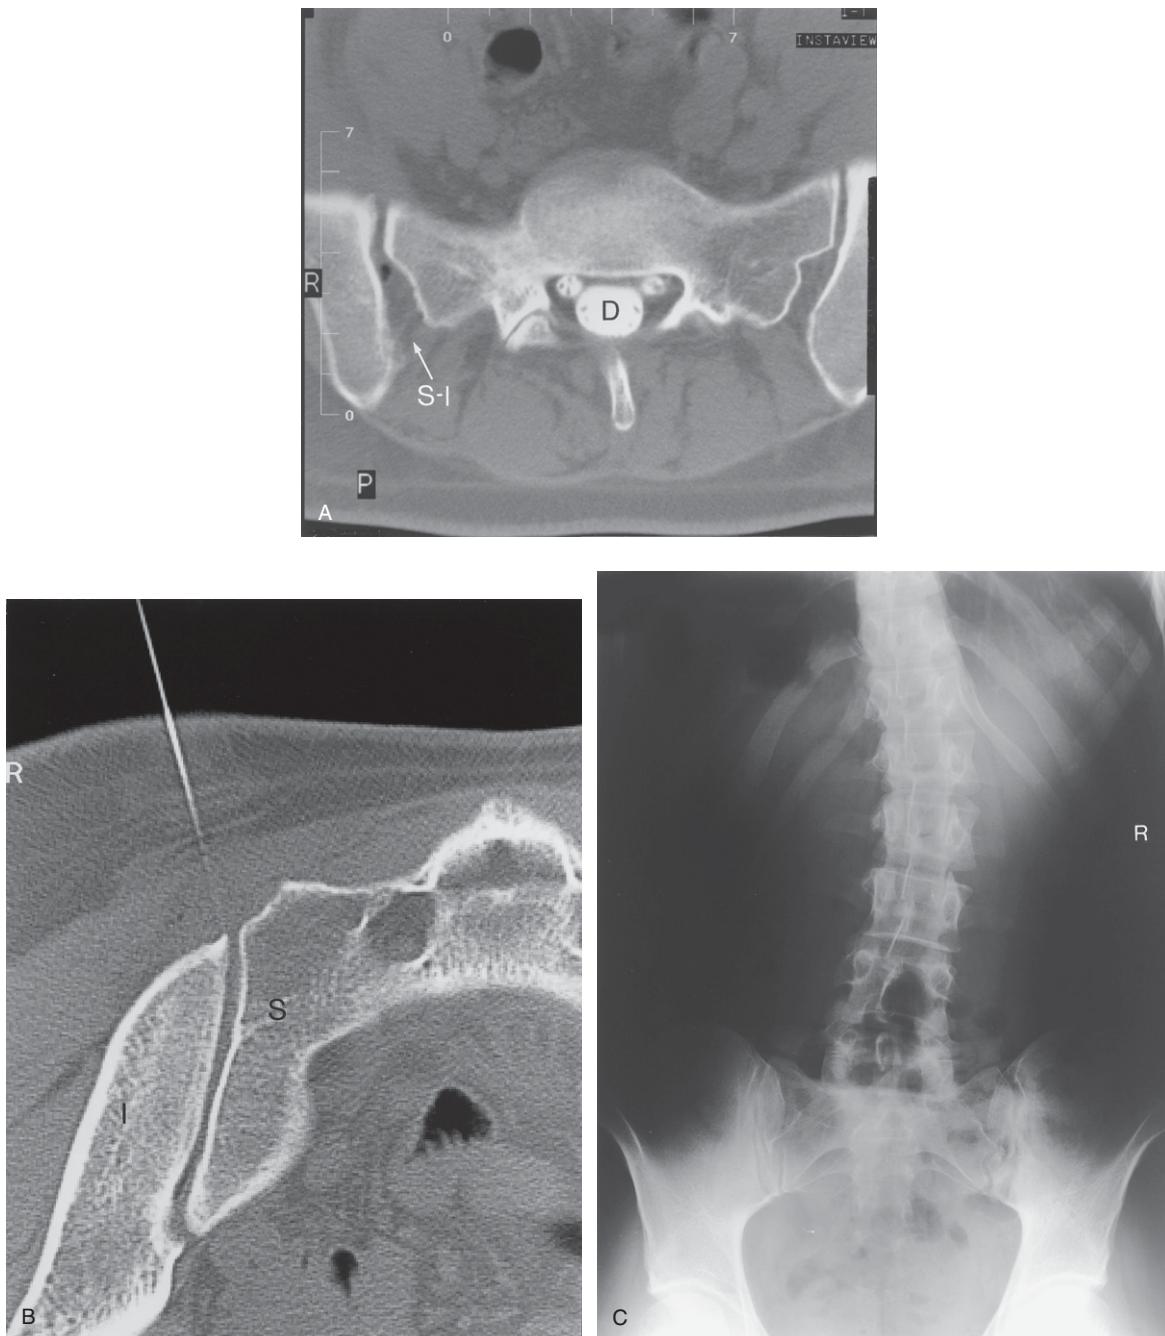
(A) CT myelogram axial image through the lower region of the lumbosacral zygapophysial joints and through the corresponding sacroiliac joint (SI) level which is above the synovial part of the sacroiliac joint. D = dural tube containing contrast material and some cauda equina nerve roots (grey dots) with adjacent nerve roots in the dural sleeve on the left and right sides, respectively. (B) CT image of the right sacroiliac joint showing needle placement for injection of the joint. I = ilium; S = sacrum. (C) Erect posture anteroposterior plain X-ray image (viewed from behind) showing the sacroiliac joints and the mild idiopathic scoliosis of the lumbar spine. R = patient's right side.
